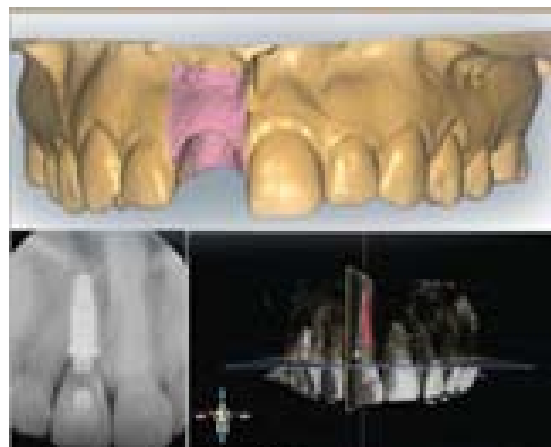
Digital planning and visualization of dental implant placement using 3D imaging and radiographic assessment.¹⁵
